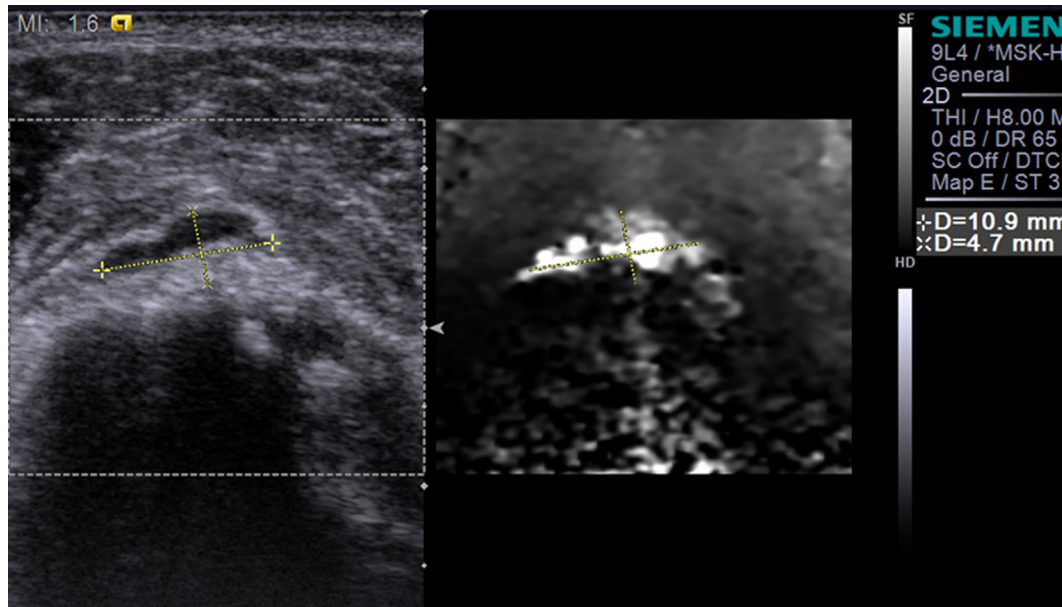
Imaging studies from a 57-year-old man who complained of severe right shoulder pain for 6 months. Gray-scale ultrasound (US) showed cystic type calcific tendinosis (dotted line), and the elastography exhibited a bright pattern (dotted line). This patient received US-guided aspiration and had pain relief.
